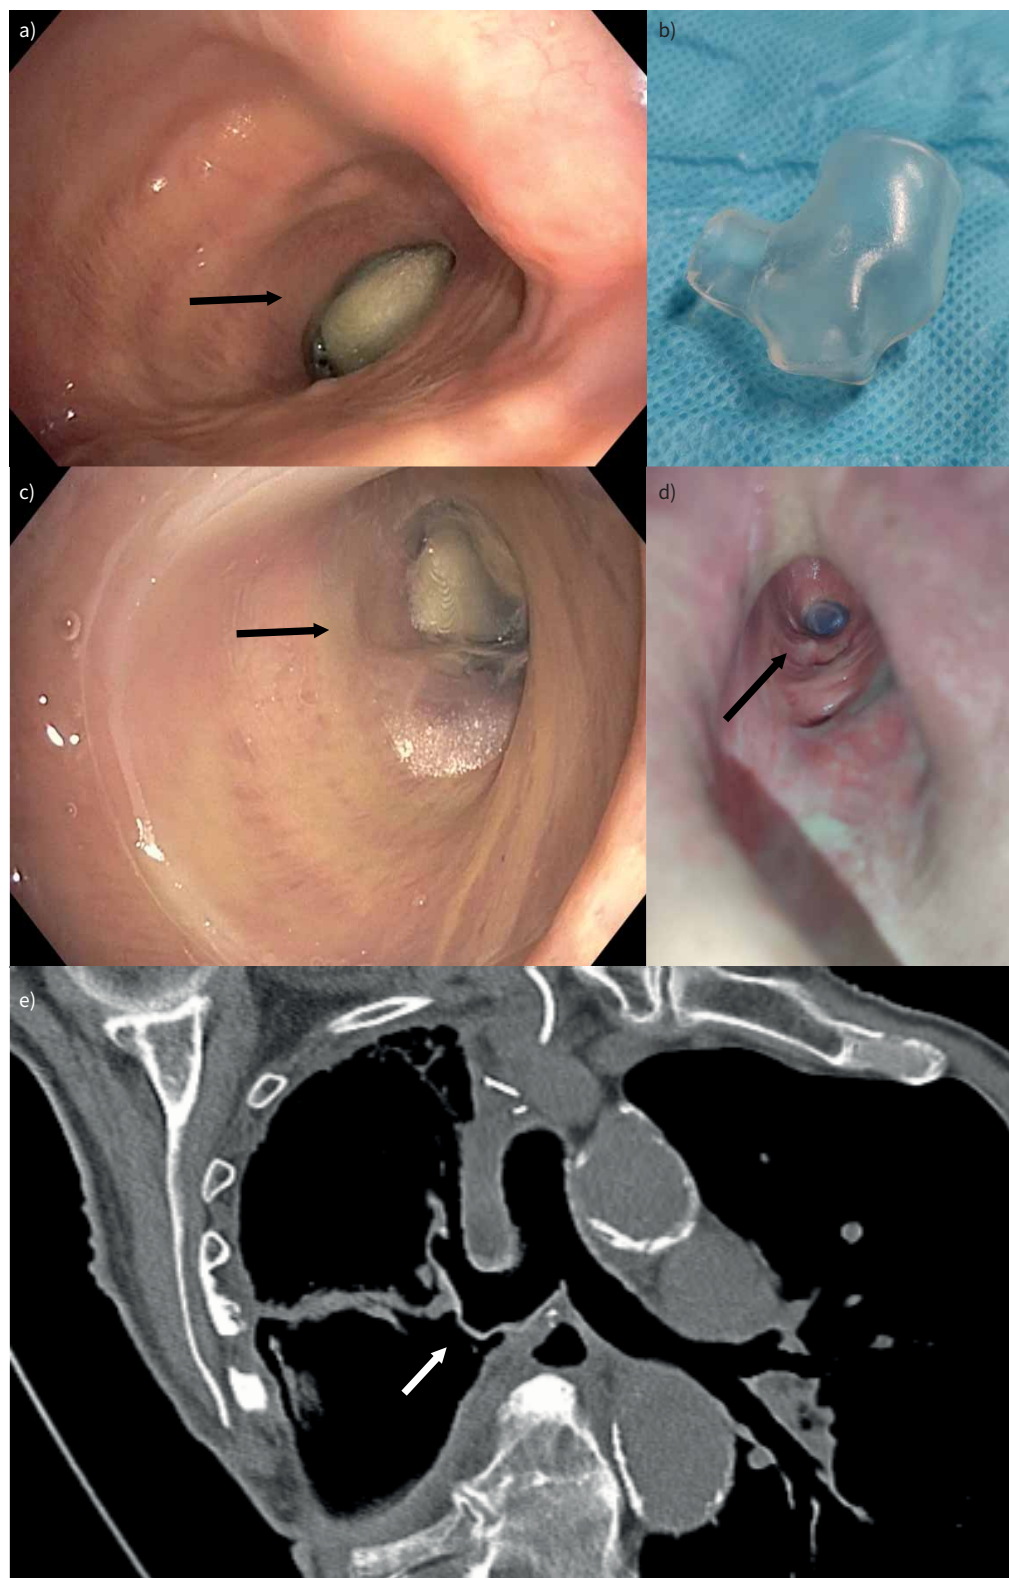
a) Endobronchial view of the fistula before stent insertion, showing a gauze in the opening. b) Customized silicone stent using 3D reconstruction of a computed tomography scan. c) Endobronchial and d) thoracostomy views of the fistula after stent insertion, covering the fistula without occluding the right upper lobe. e) Computed tomography image showing perfect fit of the customised stent, covering the fistula.
